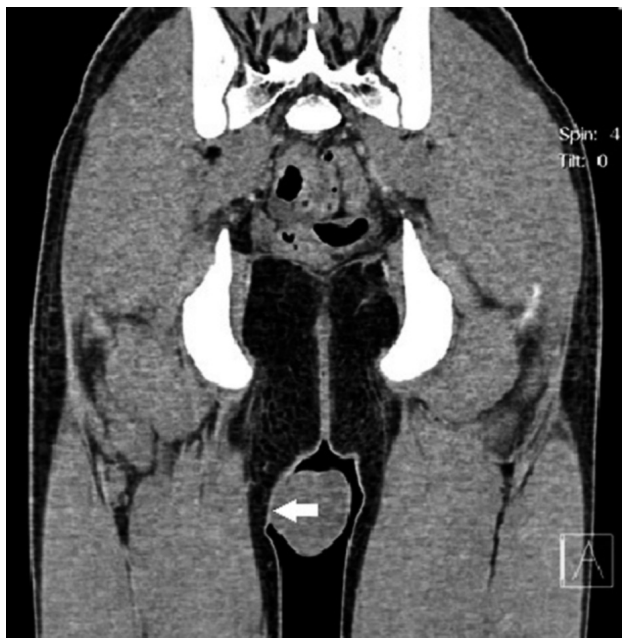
Anterior contrast-enhanced CT scan shows a superficial soft tissue mass. Nonhomogeneous accumulation of contrast can be seen. It does not appear to invade the adjacent subcutaneous fat (white arrow)
